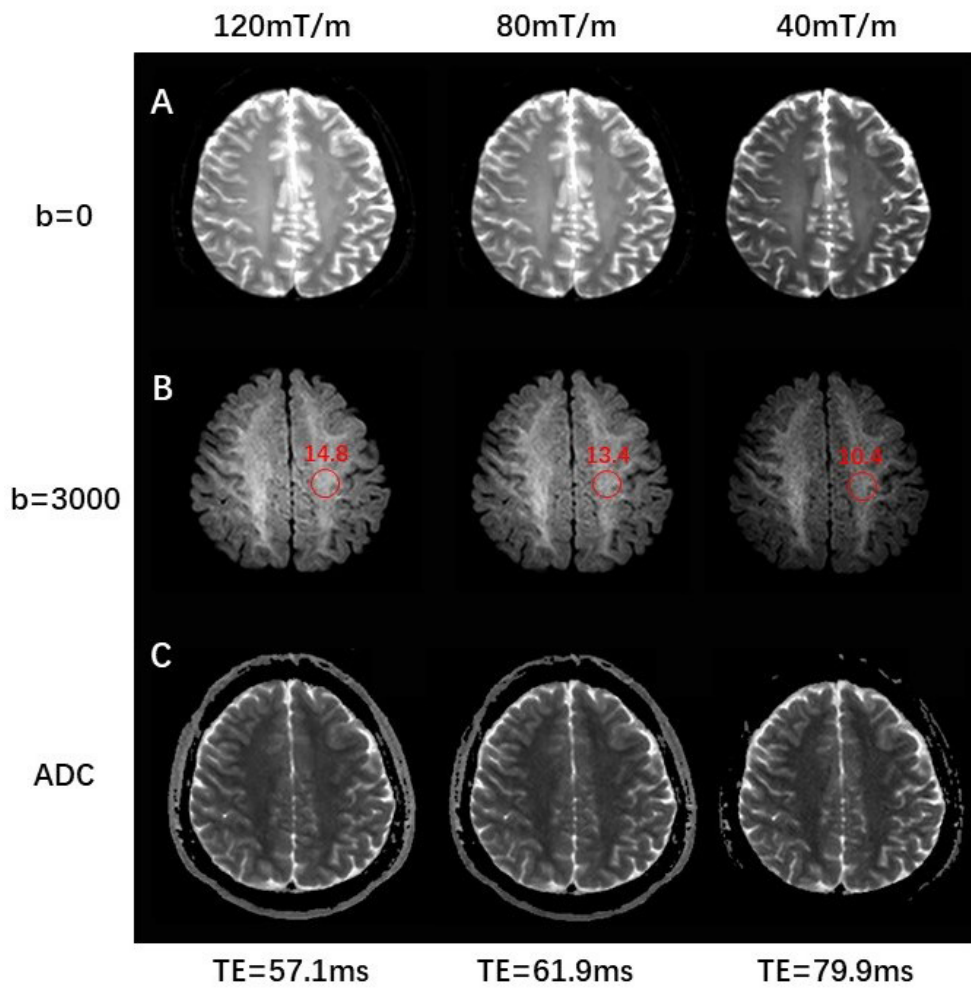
The diffusion images and apparent diffusion coefficient (ADC) images using different gradient strength at 5T MRI. The b3000 images are shown with an appropriate window level, while the other images are displayed with the same window levels.
